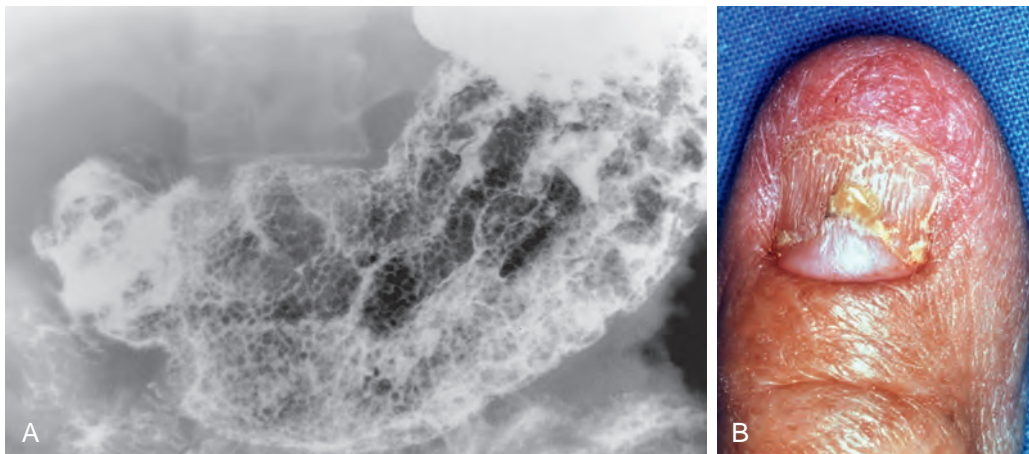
Radiographic and clinical features of Cronkhite-Canada syndrome.
